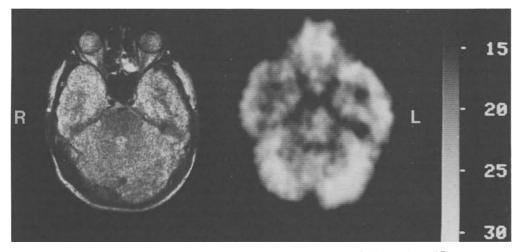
Characteristic MR (*left*) and PET images (*right*) of a 35-yearold male with complex partial seizures (evolving to generalized tonicclonic seizures) since age 18. Metabolic maps show a hypometabolic focus in the right anterior-mesial temporal pole, with the anterior part of hippocampus included. No lesion could be detected on T_2 -weighted MR images performed with TR = 1500 ms and TE = 120 ms
